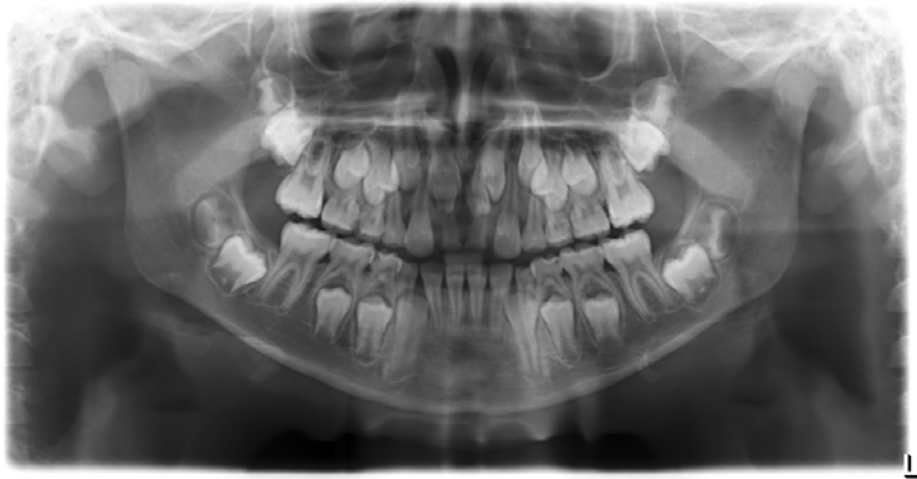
Panoramic radiograph showing impacted permanent central incisors and presence of supernumerary teeth.
